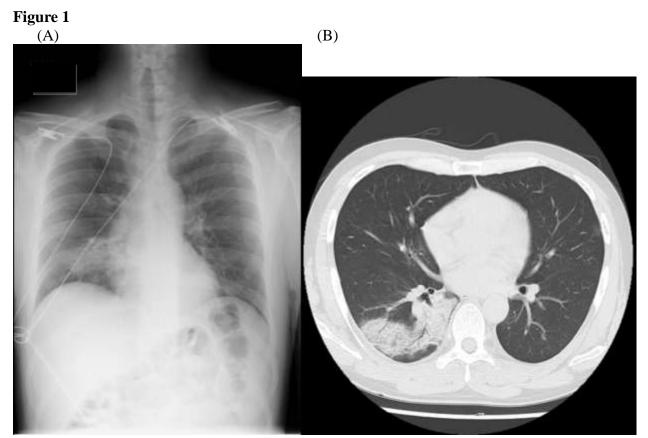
Chest X-ray (A), and computed tomography (B) findings of the 38 years old male COVID-19-related pneumococcal pneumonia patient. Massive infiltration shadow was found in lower left lung of the patient. This patient finally died although he received the appropriate treatments by remdesivir and ampicillin/sulbactam.
